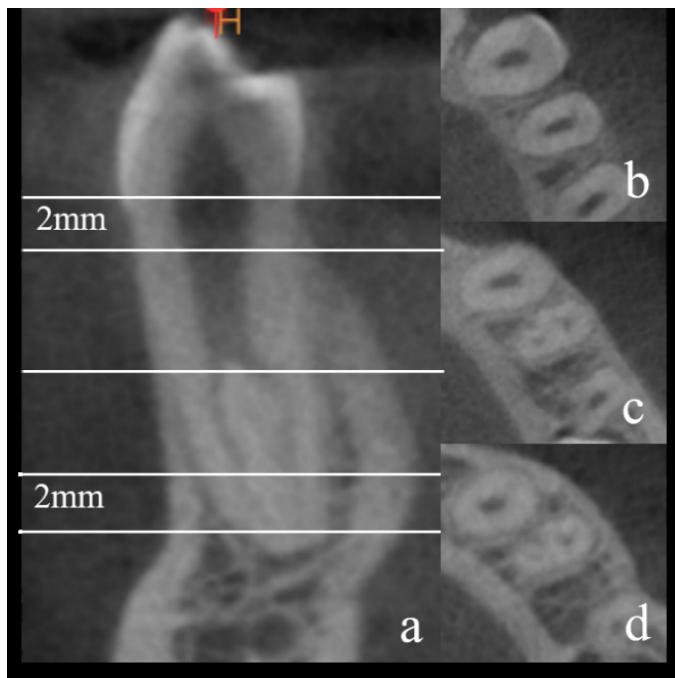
CBCT image representing the diagnosis of C-shaped configuration. (a) Frontal CBCT image showing a C-shaped mandibular first premolar. (b) Axial CBCT image showing the C4c type configuration at the coronal level. (c) Axial CBCT image showing the C2 type configuration at the middle level. (d) Axial CBCT image showing the C3 type configuration at the apical level.
